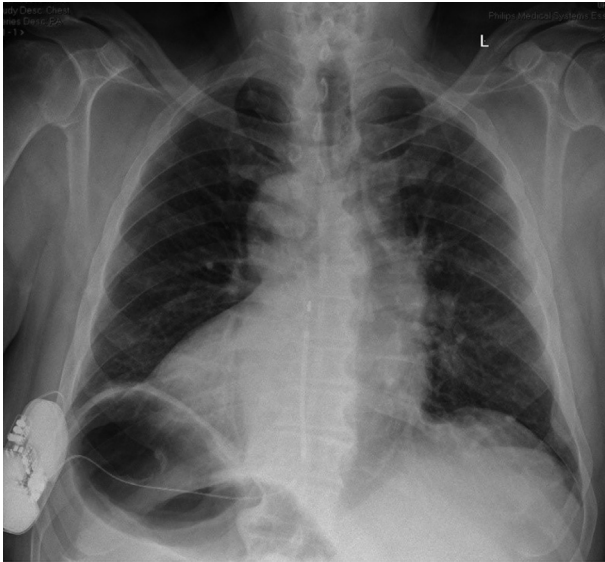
Chest x-ray posteroanterior view showing dextrocardia situs inversus with S-ICD and electrodes in place.
